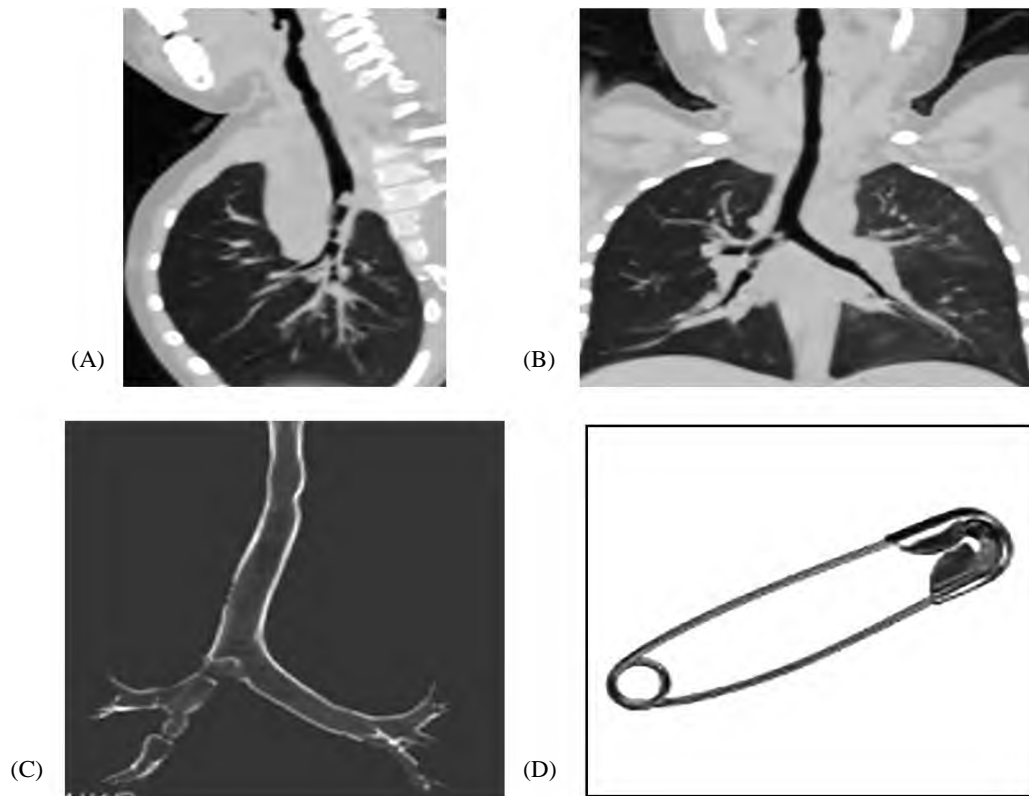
(A,B) Coronal reconstructed CT images (C) 3D volume rendering of the tracheo-bronchial tree showing right main bronchus endobronchial foreign body (pin).
